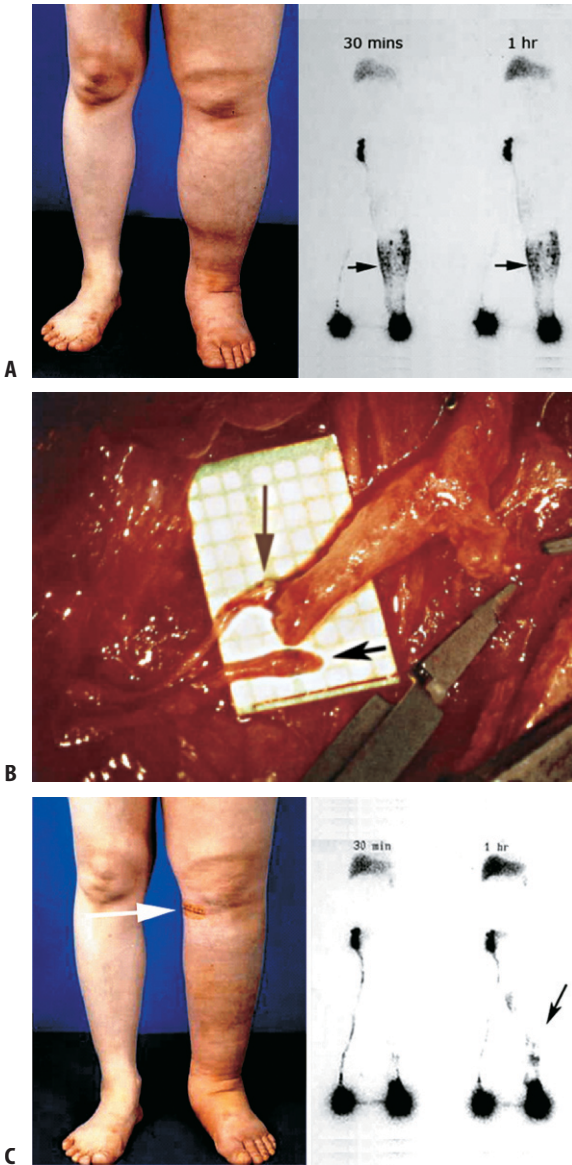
(A) Lymphovenous reconstructive surgery was performed on the left leg for progressive lymphedema, still in an early clinical stage. A preoperative lymphoscintigram shows marked dermal backflow (arrows). (B) This operative view of the popliteal area reveals functioning lymph-collecting vessels (arrows) that are to be anastomosed end-to-end to the defunctionalized vein above. (Russian method, modified by Krylov.) (C) One month after surgery, a good clinical response is noted, with less edema and improved skin turgor in the leg. The arrow points to the healing incision. A year later, dermal backflow is markedly diminished, as the scintigram demonstrates.
